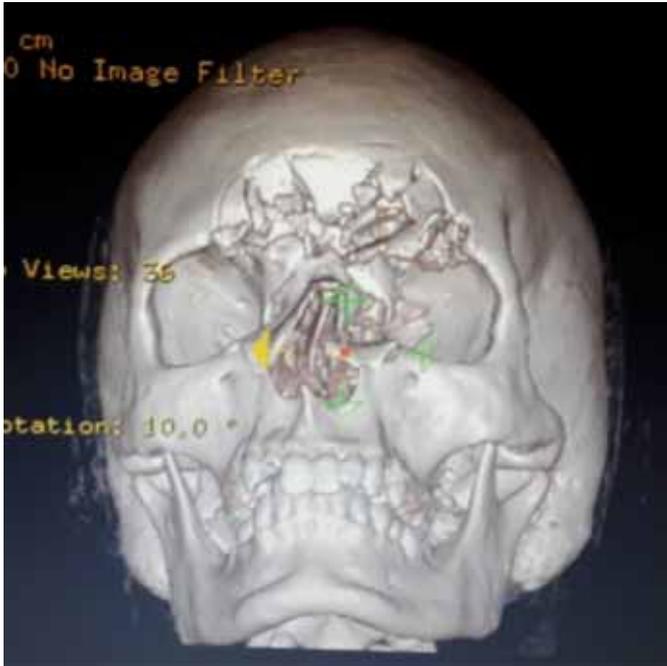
Preoperative computer tomograph (CT) image with 3D reconstruction of the viscerocranium.
